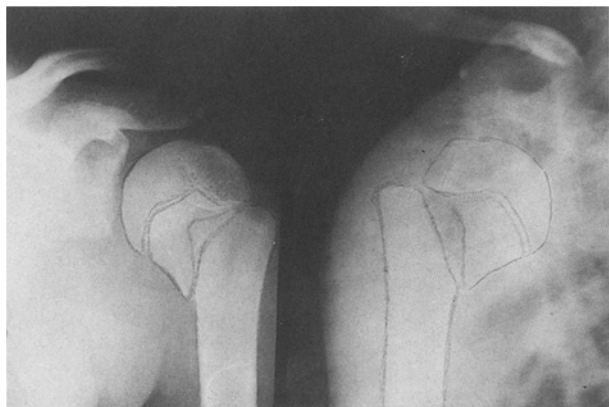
Radiograph of the most common type of displaced fracture with the distal fragment anterolateral
